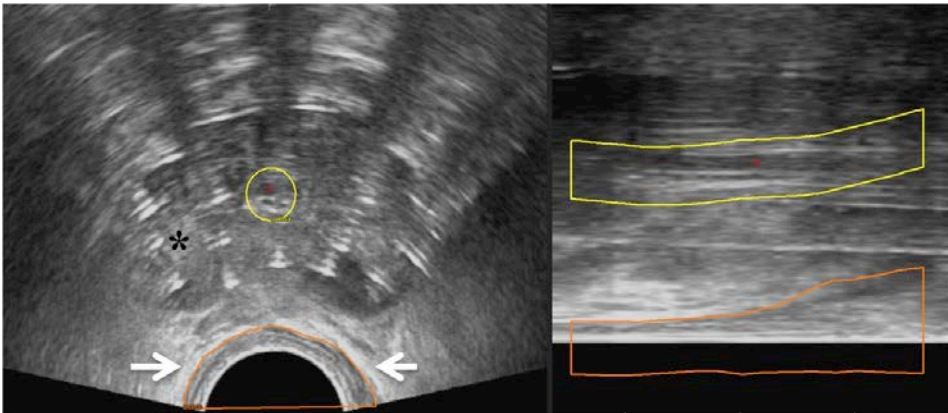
Transrectal ultrasonography-based prostate high-dose-rate brachytherapy contouring.*
